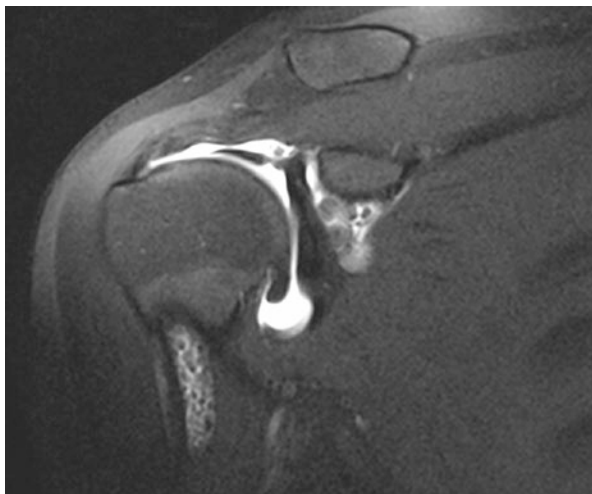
T1-weighted MR arthrogram of the coronal section demonstrating high signal near the proximal humerus and biceps tunnel and within the glenohumeral joint. Again, significant metaplastic tissue is noted within the proximal biceps and biceps groove
